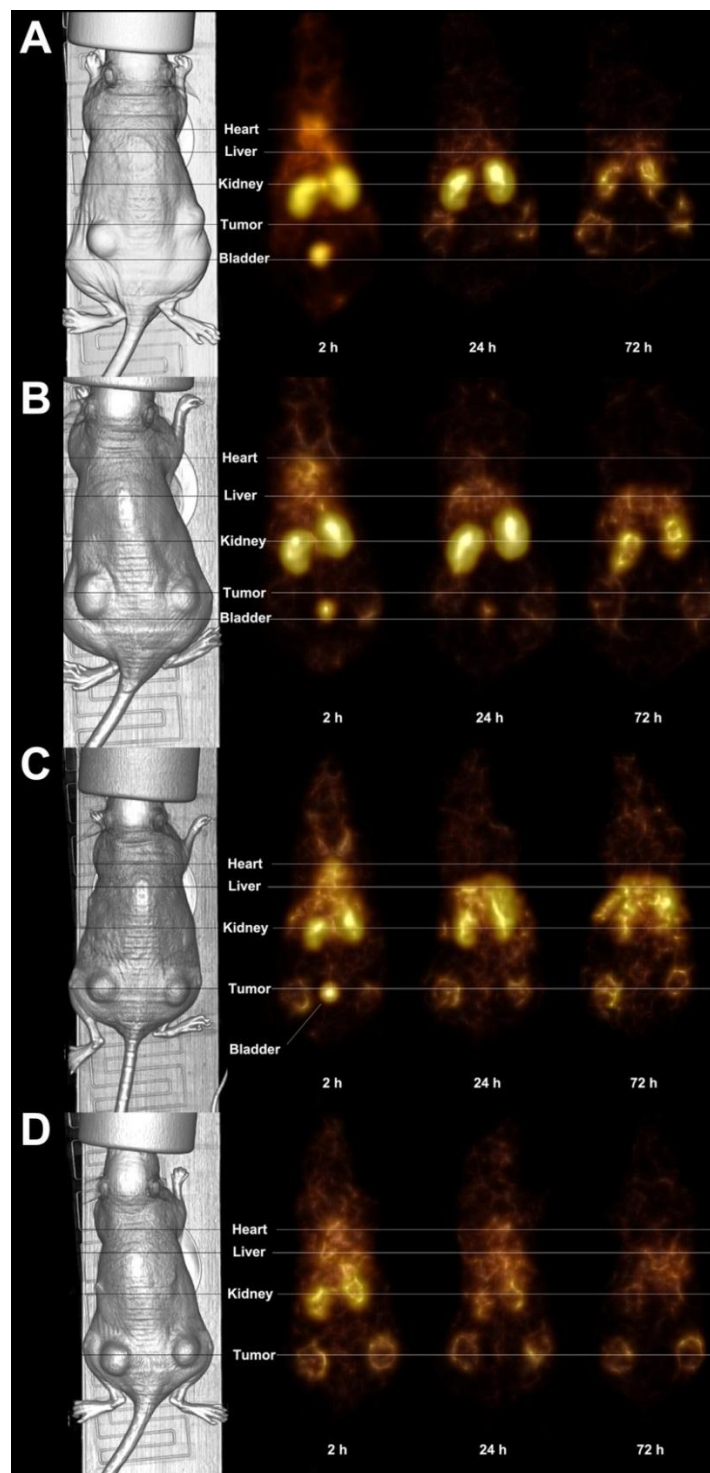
SPECT/CT imaging of conjugates treated with hyaluronidase. A) HPMA-KCCYSL- $^{111}\text{InDTPA}$. B) HPMA-KYLCSC- $^{111}\text{InDTPA}$. C) HPMA-RGDfK- $^{111}\text{InDTPA}$. D) HPMA-RGEfK- $^{111}\text{InDTPA}$. SPECT demonstrates the overall biodistribution of the HPMA-conjugates over time. Targeted conjugates had an increasing concentration in tumors over time where nontargeted conjugates decreased or reduced in concentration with respect to time.
